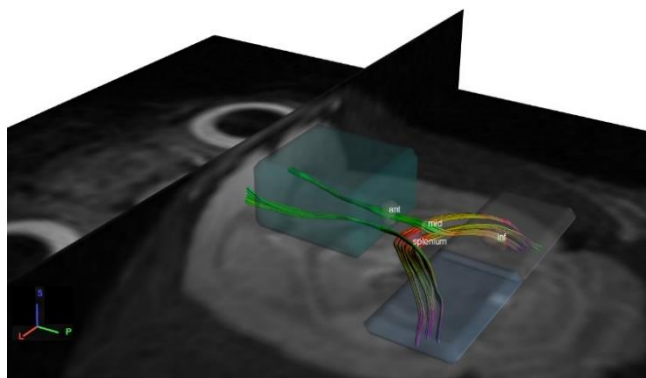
Rendering of *in vivo* MRI tractography of both cinguli and forceps maior with corresponding start and end regions (boxes), selected regions of interest in the right cingulum (ovals and text).
